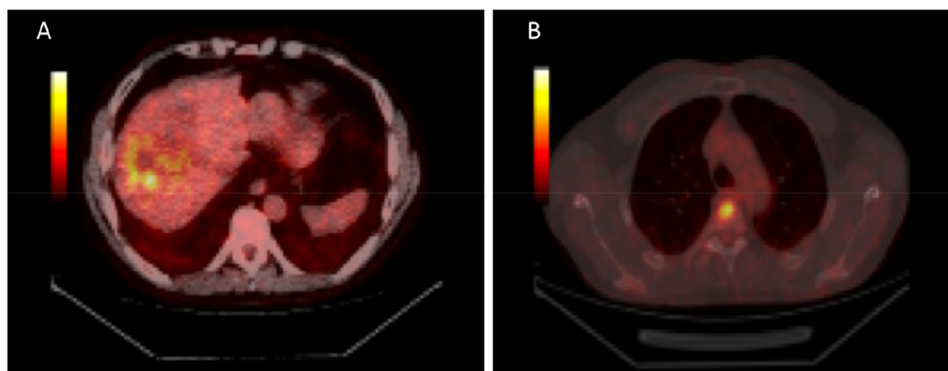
The baseline FDG-PET/CT of case 3: (A) 66×37 mm liver lesion in segment 8 with SUVmax of 5.5; (B) T3 vertebral body lesion with SUVmax 5.5.
